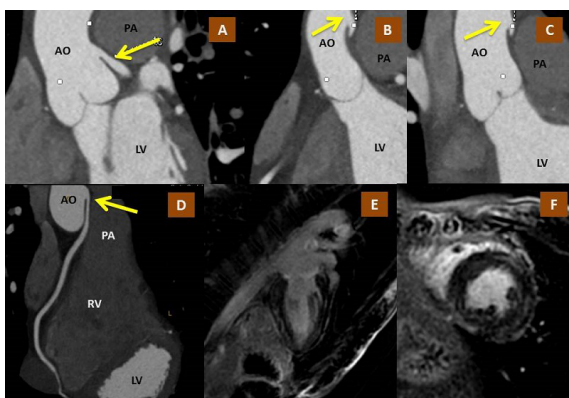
Coronary CT scan showing anomalous origin of LCA (A) and RCA (B,C,D) and Cardiac MRI showing myocardial fibrosis (E,F)
